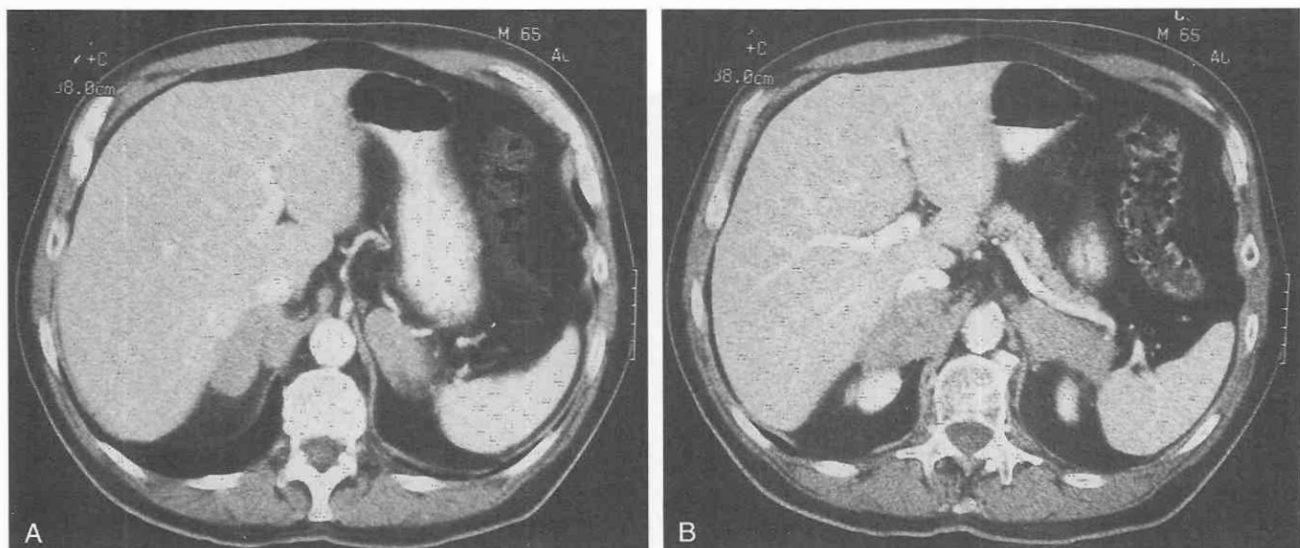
Tuberculous infection. *A* and *B*, Contrast-enhanced CT scans show infiltrating soft tissue masses shaped like adrenal glands. Percutaneous biopsy indicated acute tuberculous infection of the adrenal glands in an immunocompromised patient.
